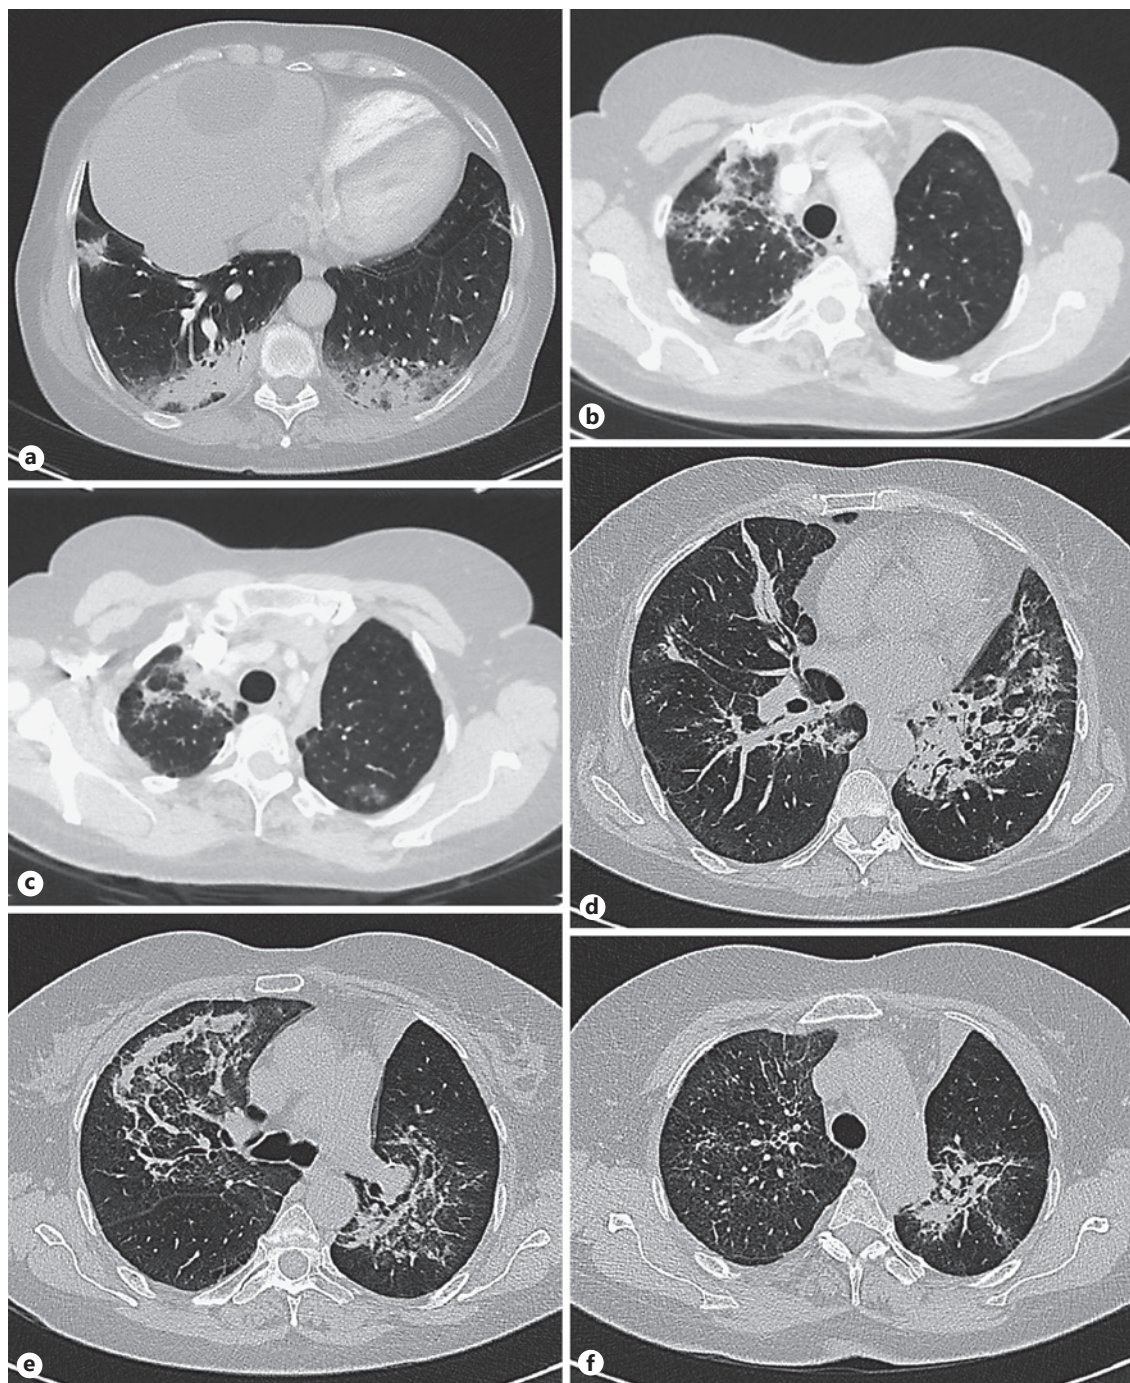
Chest computed tomography (CT) scan after seven cycles of nivolumab (January 2017). The restaging CT scan revealed lung abnormalities typical for drug-induced symptomatic pneumonitis (CTC grade 3), with multiple consolidations and ground-glass opacities in right upper and right lower lobe and left lower lobe, in which traction bronchiectasis is seen at several levels (a–c). This
